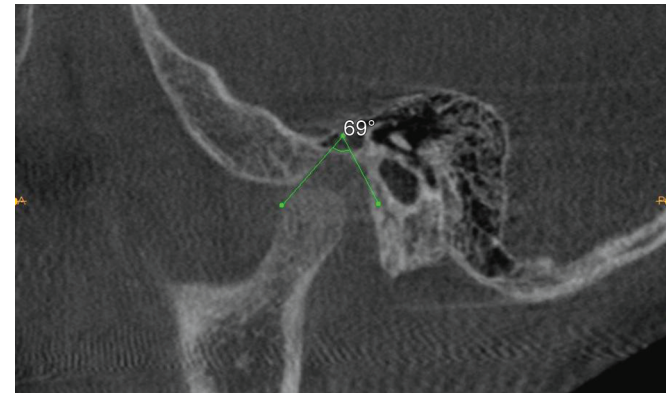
Cone-beam computed tomography (CBCT) scan of condylar angle posttreatment
